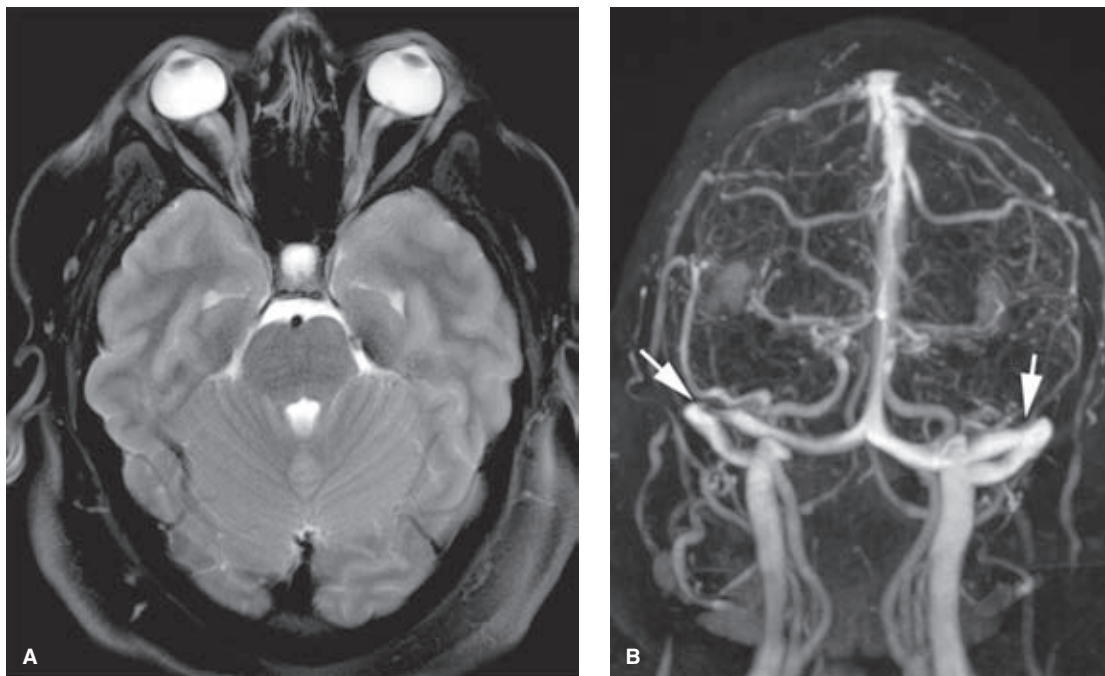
(A–F) Idiopathic intracranial hypertension treated with emergency endovascular stenting. This young female presented with precipitate loss of vision and severe headache. Her MRI (A) showed prominent bulging of the optic discs and redundancy of the optic sheaths. The gadolinium-enhanced venogram (B) demonstrates bilateral narrowing of the transverse sinuses (arrows) although the appearance is not impressive and the finding on the left has to be sought diligently on different projections in order to be seen. (continued)
